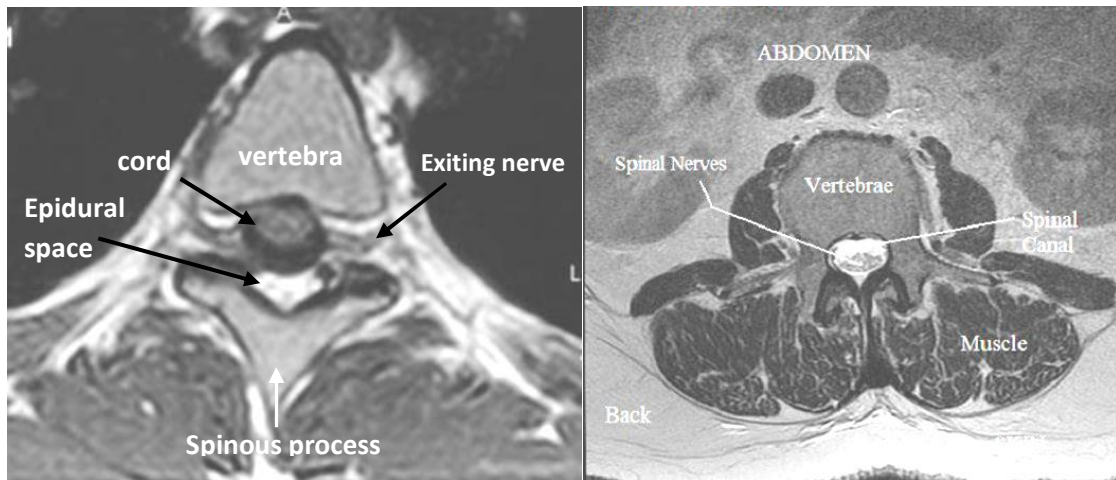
Axial T1W and T2W MRI images of the spine at different levels showing normal anatomy.
